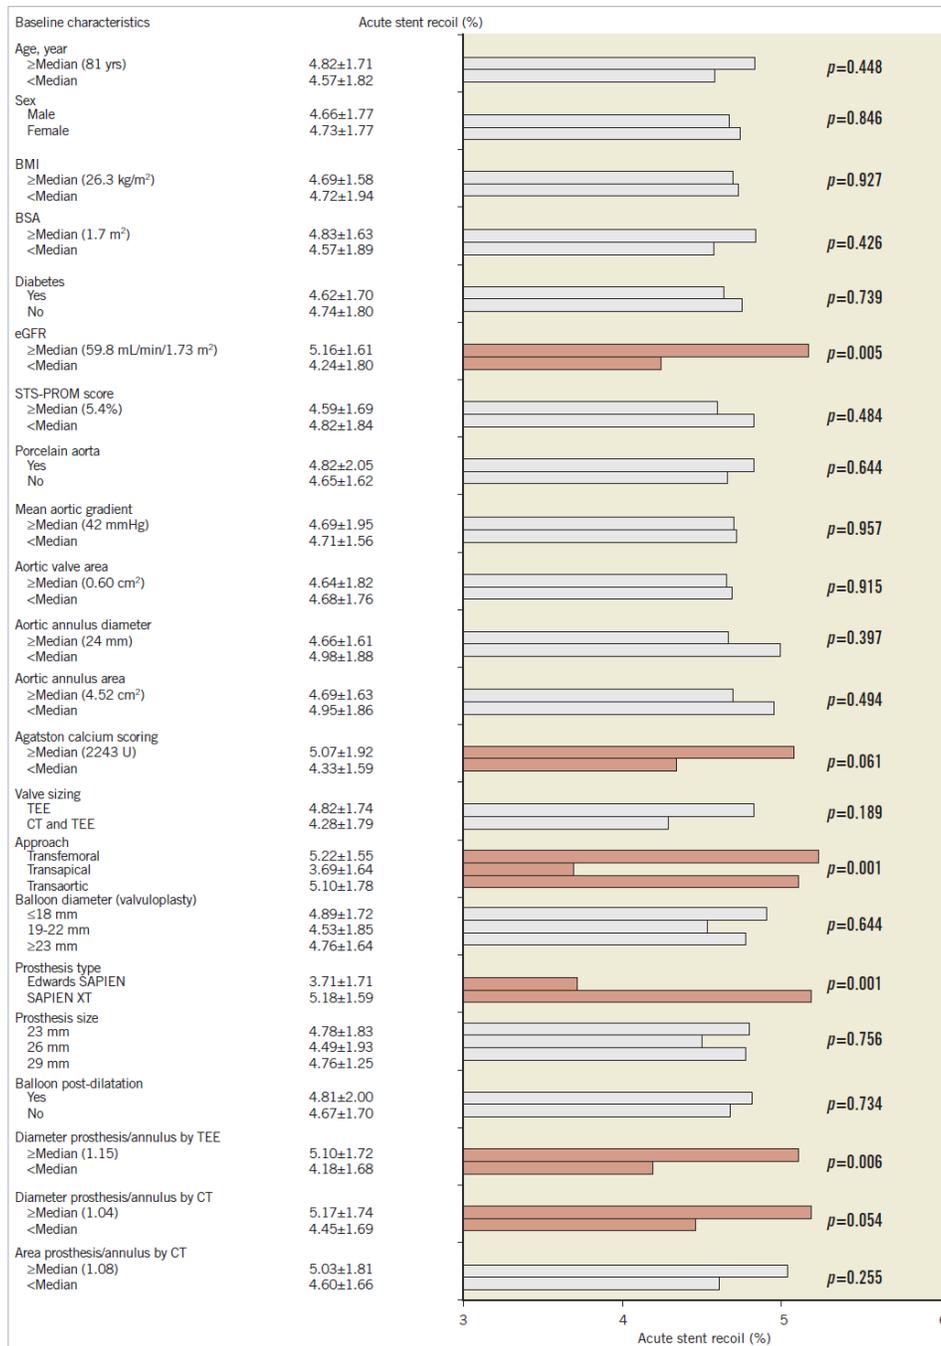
Acute relative stent recoil following TAVI according to clinical, echocardiographic, computed tomography and procedural variables. BMI: body mass index; BSA: body surface area; CT: computed tomography; eGFR: estimated glomerular filtration rate; TEE: transoesophageal echocardiography; STS-PROM: Society of Thoracic Surgeons predicted risk of mortality
